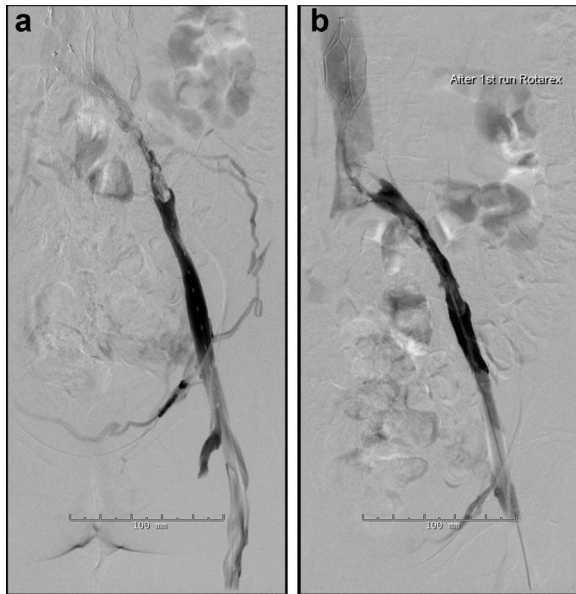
Digital subtraction phlebography showing the results after 48 hours of ultrasound-accelerated catheter-directed thrombolysis (UACDT, a) and after mechanical debulking with the Rotarex catheter (b).
